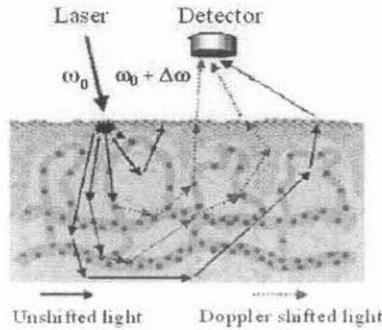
Principle of Laser Doppler Flowmeter
